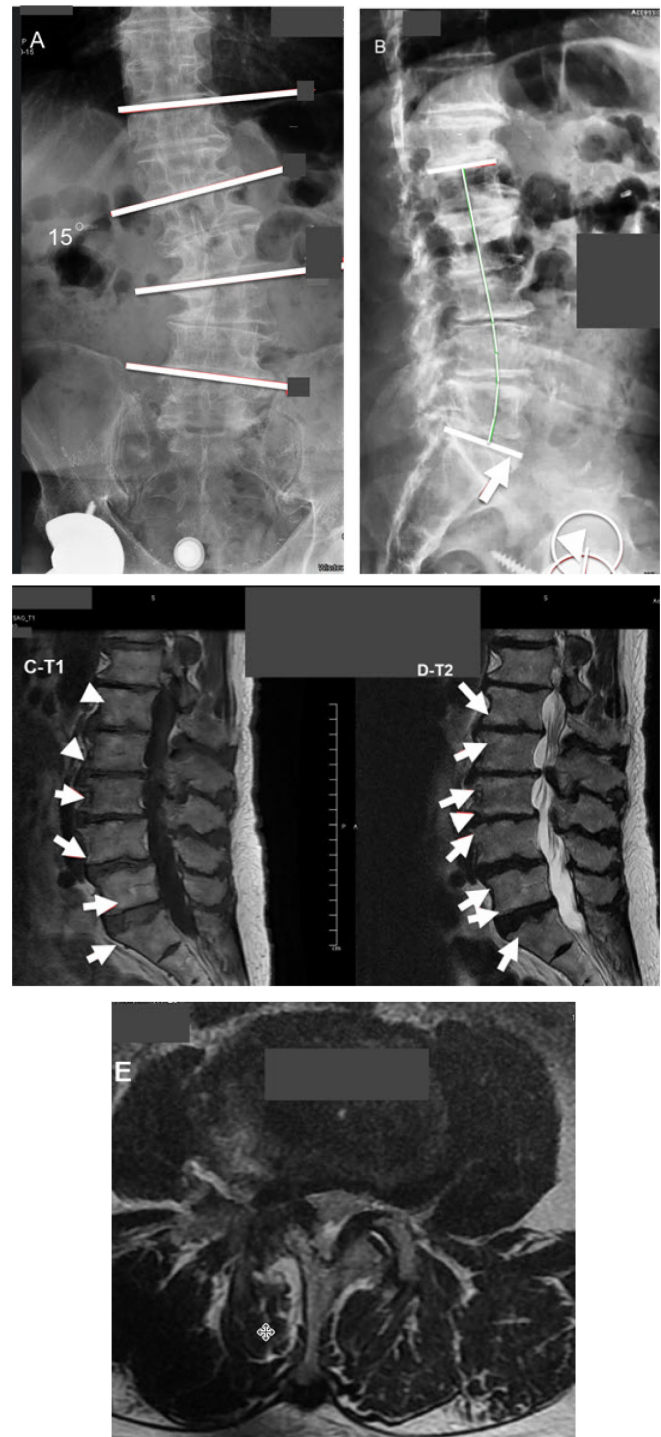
Anteroposterior (A) and lateral (B) conventional radiographs of the lumbar spine taken in a 79-year-old patient (A) with a 15° lumbar scoliosis (white lines Cobb angle measurement). (B) Sagittal imbalance with loss of lumbar lordosis (white curved line; pelvic tilt [PT] = 37, pelvic incidence [PI] = 54.4, PI-L1 = 30.7). (C) sagittal T1 and (D) T2-weighted magnetic resonance images of same patient show Modic 1 and Modic 2 changes around Schmorl's nodes vertebral endplate (VEP) damage at L1-L4 (white arrows at each VEP disruption in panels C and D). (E) T2-weighted axial image shows severe central and foraminal stenosis. This patient refused corrective subtraction osteotomy or laminectomy. After basivertebral nerve ablation (BVNA) L2-S1, VAS improved 9 cm (from 10 to 1) and Oswestry Disability Index improved 58 points (from 70 to 12) at the last follow-up. The patient was very satisfied with the BVNA result and said he would not do an osteotomy.
